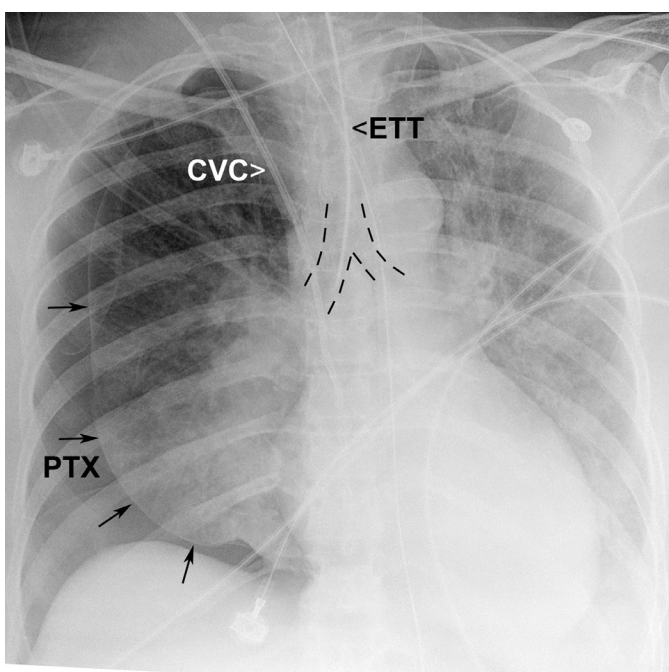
■ Anteroposterior (AP) chest x-ray. Right main stem bronchus intubation resulting in a right pneumothorax (PTX), outlined by arrows. Background of interstitial pulmonary edema. Atelectasis and a pleural effusion obscure left hemidiaphragm and cause a “retrocardiac density.” CVC, central line; ETT, endotracheal tube.
